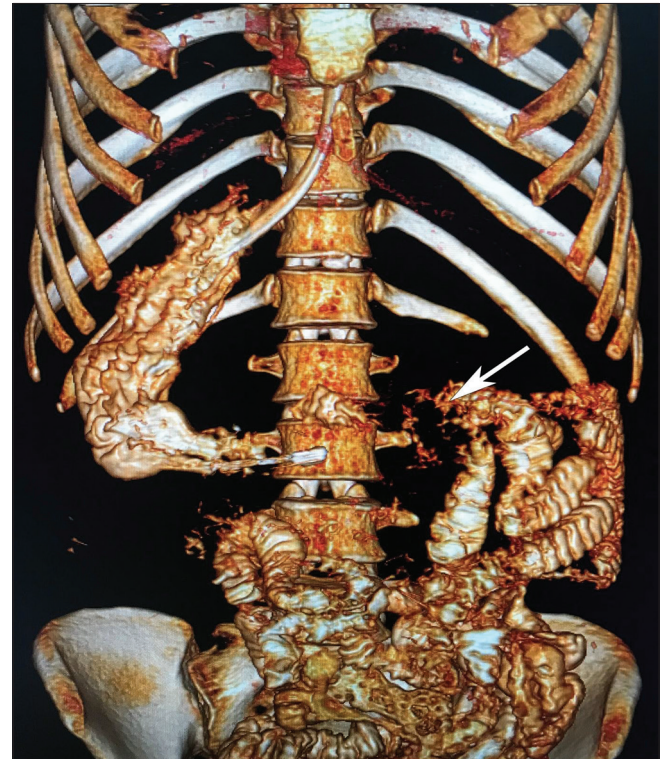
The coronal reconstructed view of CT abdomen shows the duodeno-jejunal junction displayed left lateral to L2 vertebra
